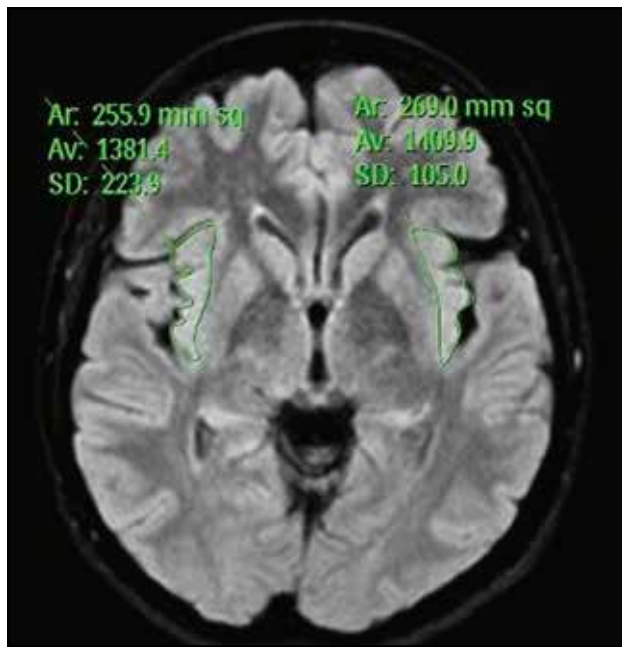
On axial FLAIR MRI scan, the insular gyrus area is measured at maximum section as mm².
